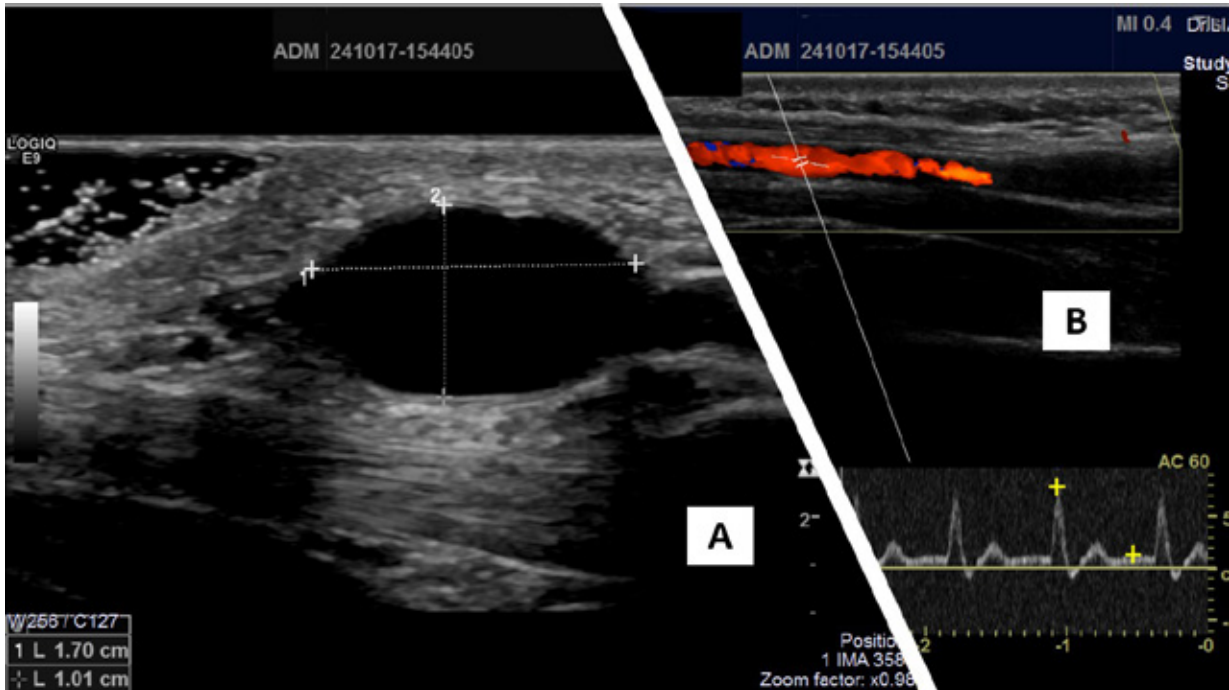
A. Preoperative imaging of the 1,7cm ulnar artery aneurysm using color doppler ultrasound with B. normal waveforms.
